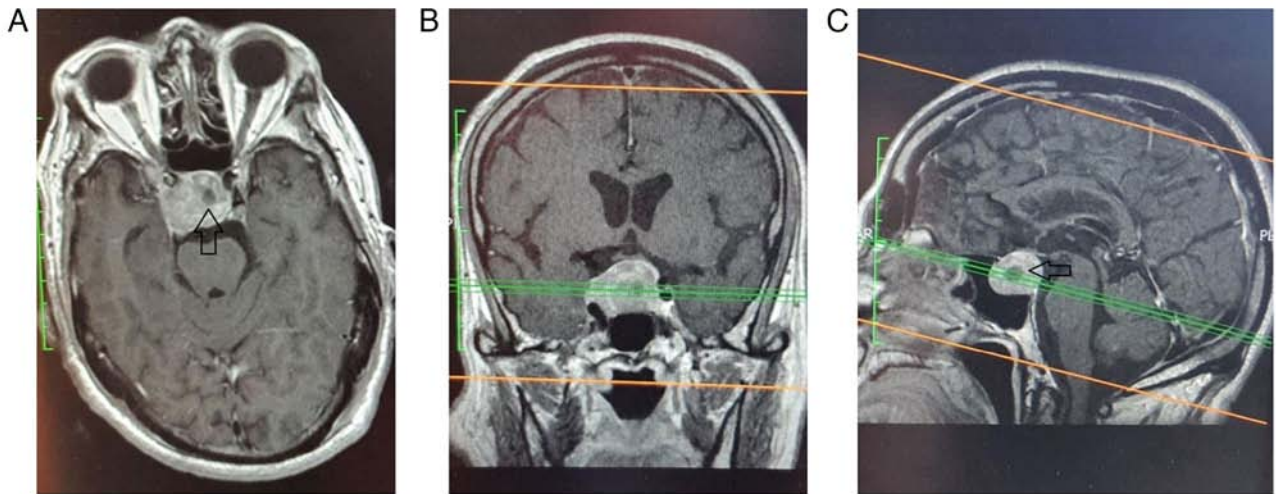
(A-C) Pre-operative contrast enhanced T1 MRI scan of patient 4, depicting a pituitary macroadenoma with internal bleeding (arrows). The patient presented with clinical signs of pituitary apoplexy.
